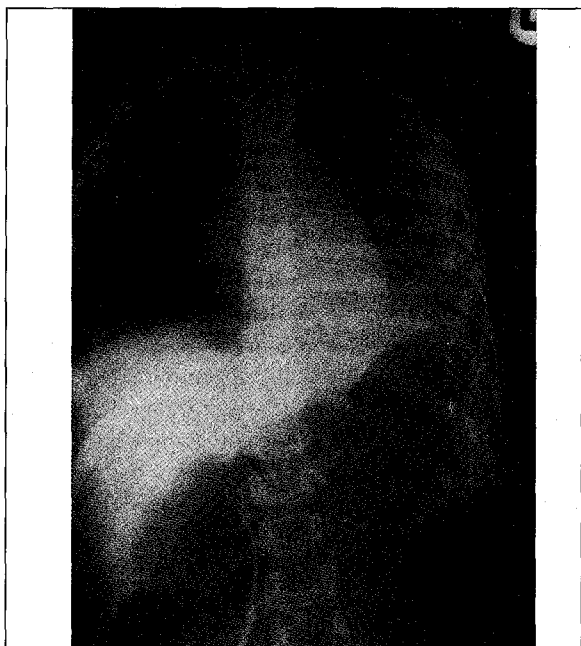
Chest radiograph showing dilated loops of bowel
